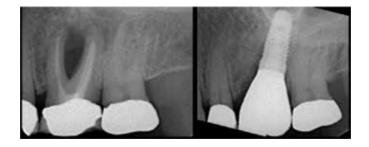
Before and after radiographs.
